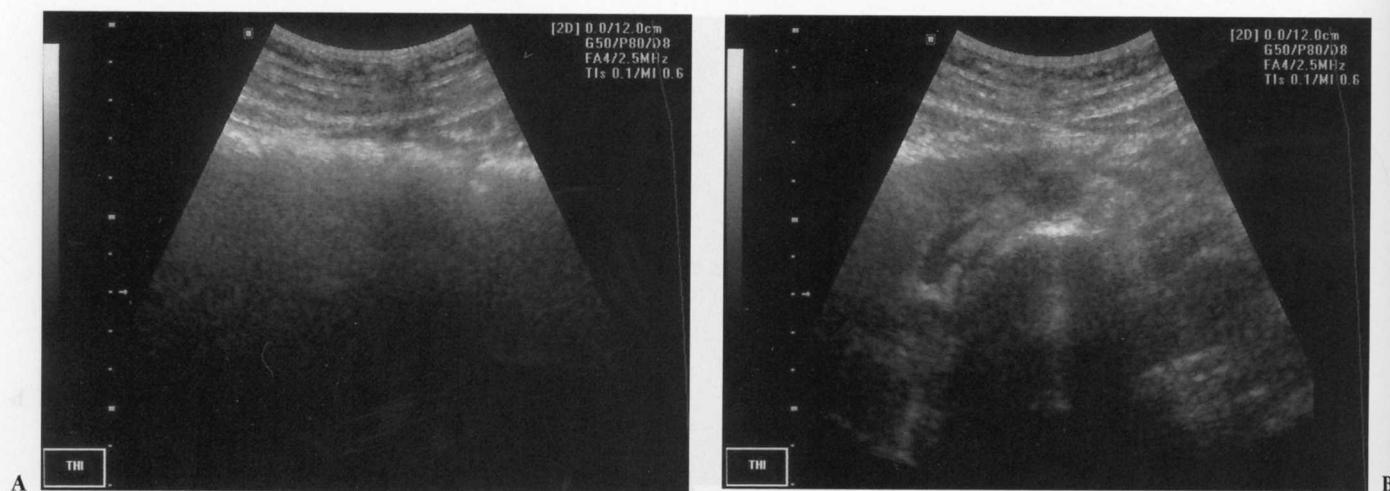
Ultrasound image of bowel gas obstructing views of the aorta (A). Ultrasound image of the same patient after gentle transducer pressure and peristalsis has decreased shadowing from bowel gas to allow visualization of the aorta (B).
